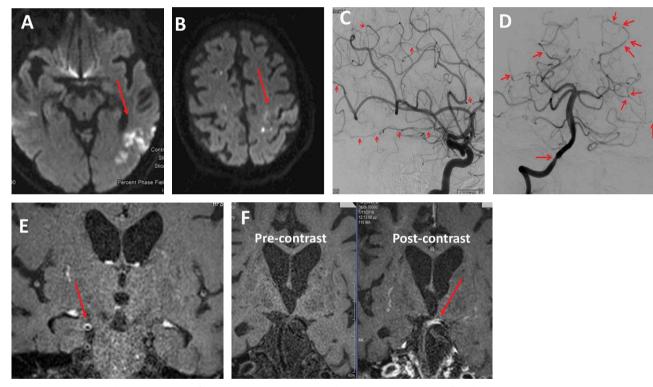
A 73-year-old male was transferred to our department with an eight-day history of limb weakness and gait unsteadiness. His medical history was remarkable for colon cancer surgically treated 20 years ago, coronary heart disease and diabetes. Neurological examination revealed paraparesis and left arm ataxia. Brain MRI demonstrated multiple infarcts of different time points and in several arterial territories (acute ischemic lesions in the left temporal lobe and subacute middle/anterior watershed ischemic lesions) (Panel A). An embolic mechanism was suspected, and a transesophageal echocardiogram demonstrated a mobile atheromatous plague in the ascending aorta. The patient received double antiplatelet therapy (aspirin and clopidogrel) and rosuvastatin. Nine days later, he developed right facial palsy, right hemiparesis, and bilateral upper limb ataxia. A new MRI scan demonstrated new acute infarcts in the right parietal lobe and the left precentral area (Panel B) as well as prominent leptomeningeal enhancement. An extensive panel of blood test examinations were within normal limits. CSF protein concentration was 170mg/dl, and the rest of the CSF analysis was normal. DSA demonstrated the involvement of multiple large and medium-sized vessels, with multiple alternating areas of vessel stenosis and dilatations (Panels C&D). 3D HRVWI-MRI showed concentric vessel wall enhancement in the multiple stenotic arteries, namely the middle cerebral arteries and the basilar artery (Panels E&F). PACNS diagnosis was established based on the currently available diagnostic criteria and the patient was treated with 1g intravenous methylprednisolone for five days followed by oral prednizolone 100mg/day and monthly intravenous CYC pulse doses. However, his situation continued to deteriorate, so rituximab infusion as a rescue therapy was introduced, but unfortunately without significant response to treatment. This is a case of highly active and aggressive PACNS with minimal response to first- and secondline treatment regimens.
